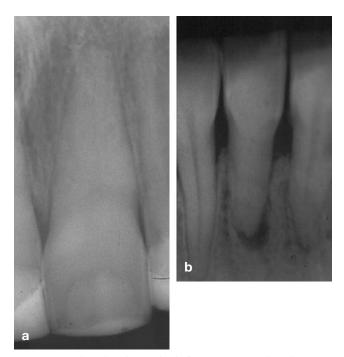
Teeth with pulp canal calcification. (A) Tooth 21 has a clinically normal pulp with no evidence of periapical pathosis but there are radiographic signs of pulp canal calcification. Endodontic treatment is not required for this tooth. (B) Tooth 41 has a pulpless, infected root canal system with chronic apical periodontitis. There is radiographic evidence of pulp canal calcification. Endodontic treatment is required for this tooth.
